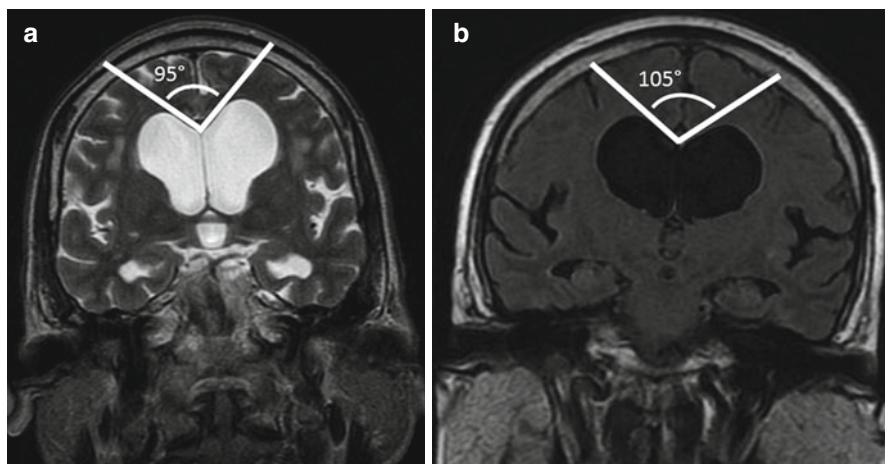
(a) A 67-year-old male with slight cognitive impairment, progressive gait disturbance, and occasional urinary incontinence. Neuroradiological examinations from July 1993 show progressive ventricular enlargement. In the last MRI (June 2012), the Evans' index is $59.4 \text{ mm}/137.60 \text{ mm}=0.43$, and on T2 coronal image at the level of the posterior commissure, the callosal angle is more than 90° . After a positive tap test, a programmable shunt was inserted. Ten months after surgery the patient has a lasting clinical benefit on gait disturbance and urinary incontinence. (b) A 64-year-old female with gait instability and urinary incontinence. On MRI the Evans' index shows $47.4 \text{ mm}/127.1 \text{ mm}=0.37$. On coronal T1 image at the level of the posterior commissure, the callosal angle is more than 90° . Two years after surgery the patient is asymptomatic. The callosal angle must be interpreted in association to the clinical symptoms and all the neuroradiological findings
